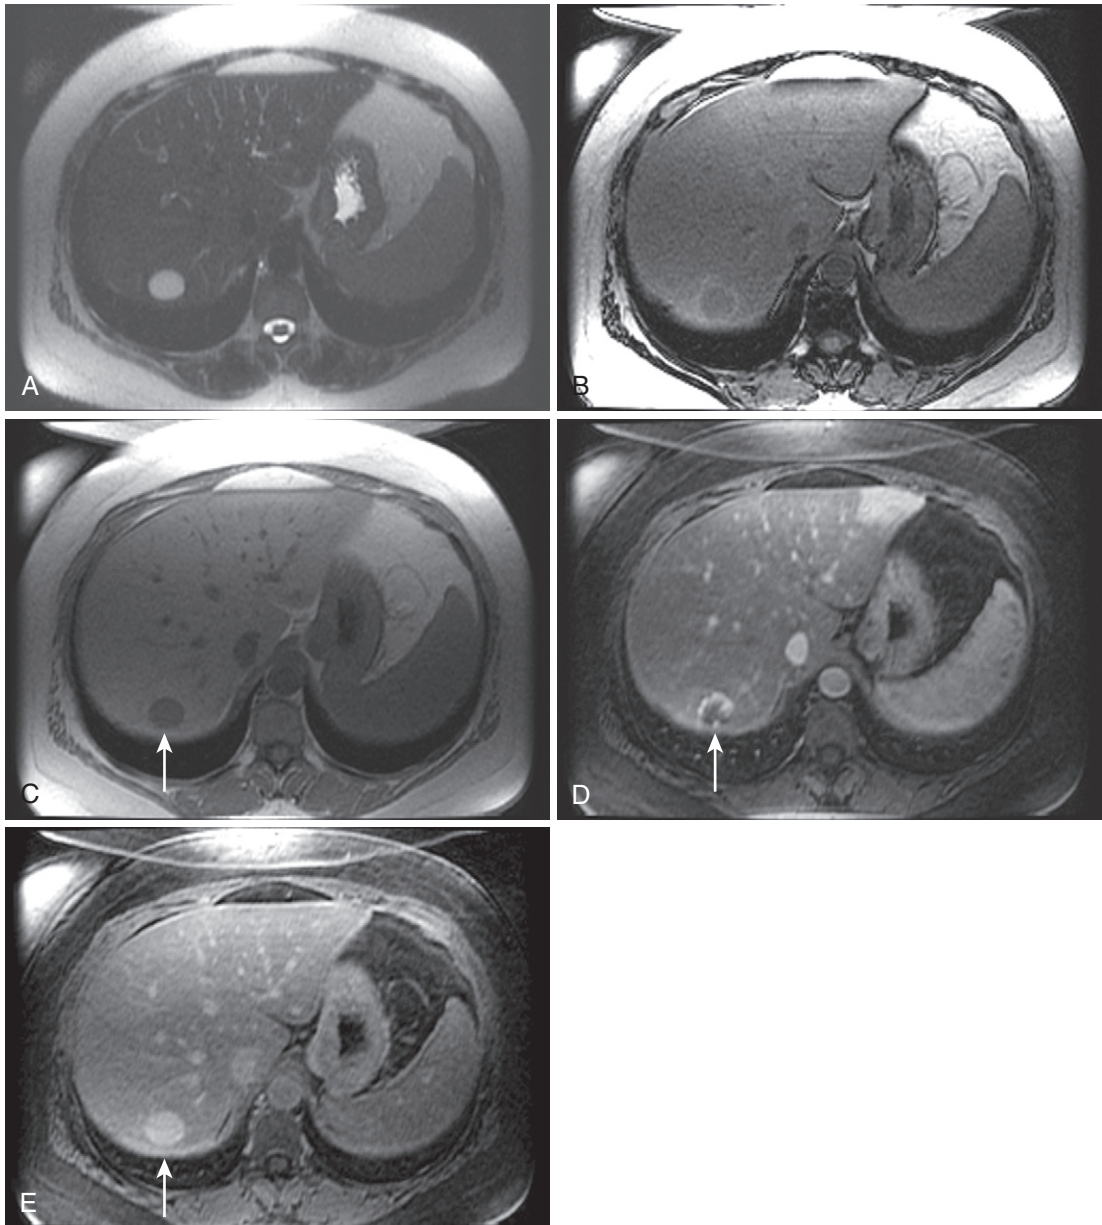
Liver MRI obtained on a 1.5-Tesla system. In-phase (A) and out-of-phase (B) images demonstrate steatosis reflected by relative signal loss on the out-of-phase image. Axial T2-weighted single-shot fast spin-echo (SSFSE) image (C) reveals a small hyperintense lesion (*arrow*) in the posterior segment of the liver. The axial arterial (D) and delayed (E) images show initial clumped, peripheral, discontinuous enhancement with uniform, persistent enhancement (*arrow*). Note the higher signal-to-noise (SNR) and improved image quality compared with [Figure 2-1A–D](#).
